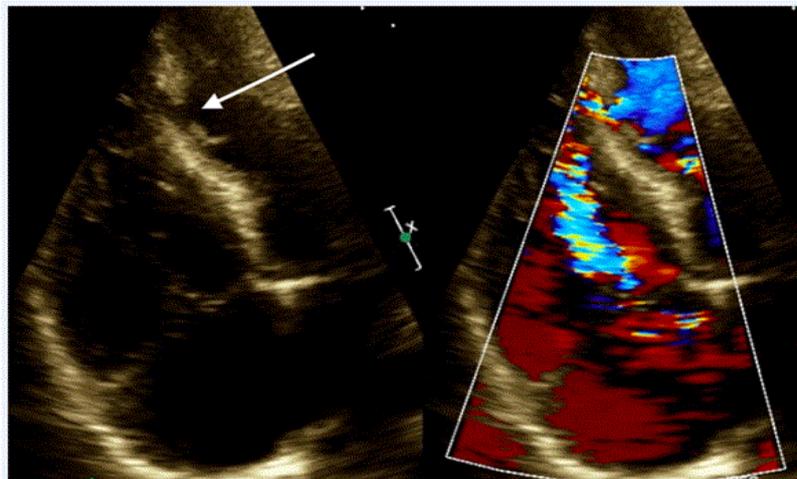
Echocardiogram demonstrating VSD and significant intra-cardiac shunting (white arrow)
